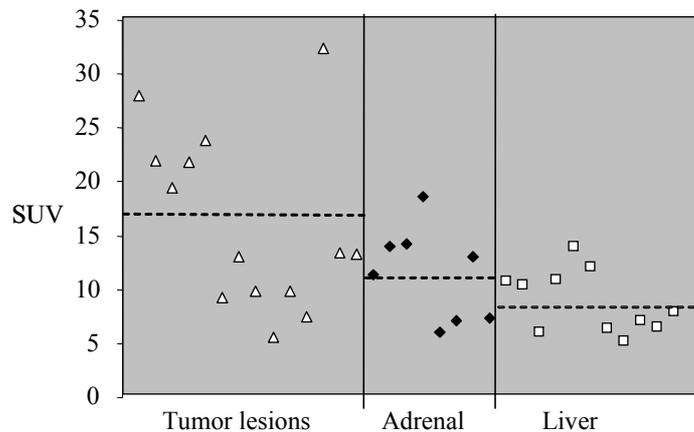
SUVs for ROI_{hs} in tumor tissues, adrenals and liver. Dotted lines represent the mean SUV
